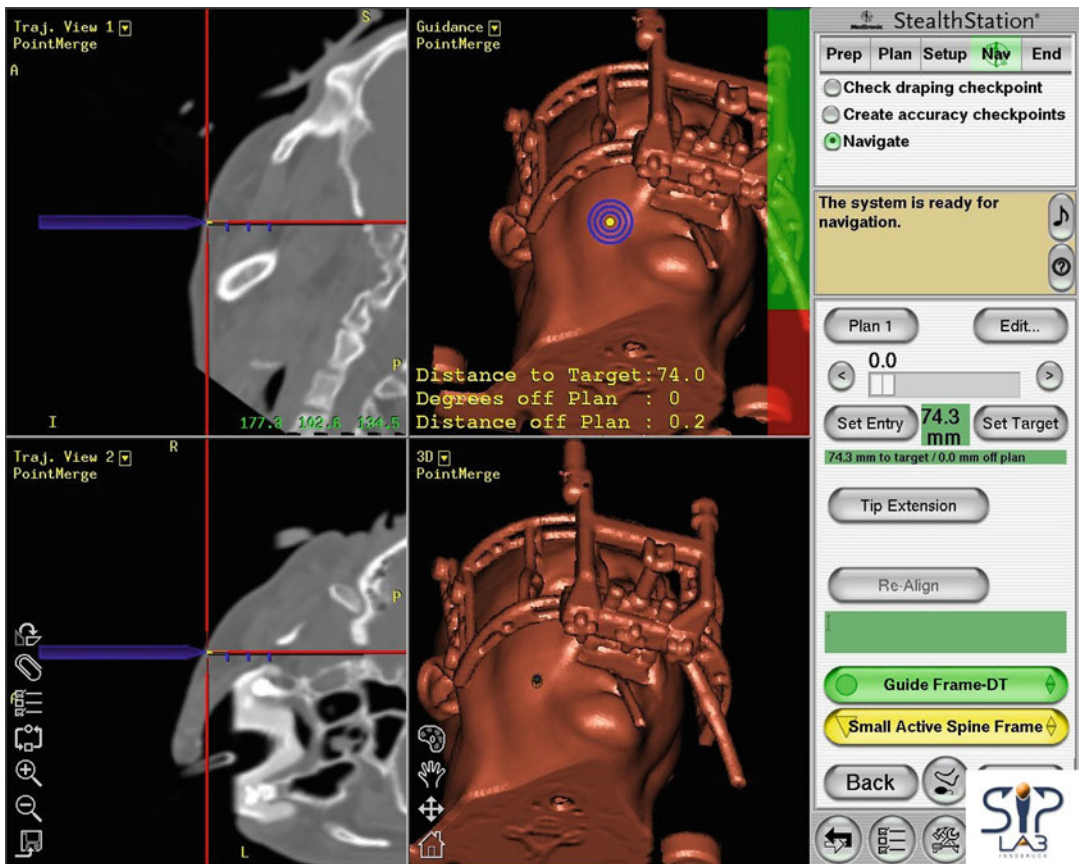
Pathplanning on 2D- and 3D-reconstructed CT data. The blue line indicates the trajectory through the foramen ovale
